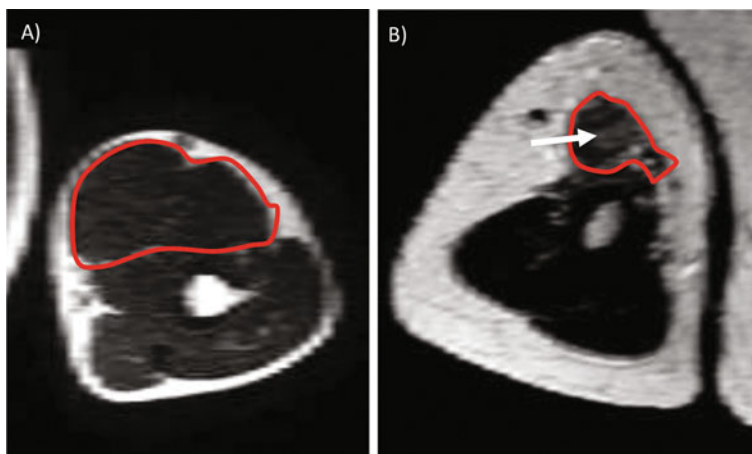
T2-weighted MRI scans of uninjured and nerve injured biceps muscles from patient who sustained C5/6 Avulsion. (a) Uninjured biceps muscle (uninjured contralateral arm) outlined in red. (b) Subacutely denervated biceps muscle (3 months following injury) demonstrating increased signal (arrow) and muscle atrophy of biceps muscle (outlined in red) compared to (a)
